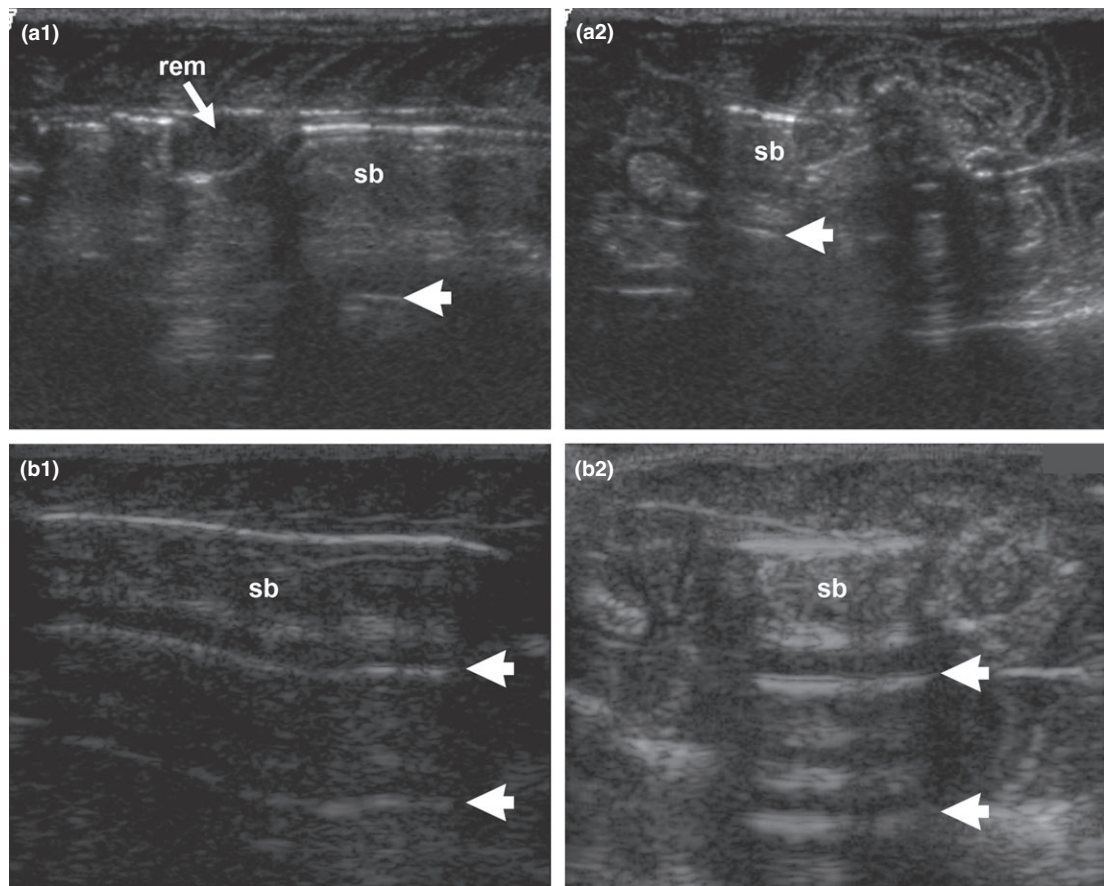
Anguilla anguilla*, no. 5. (a1) Longitudinal and (a2) transverse high-end ultrasonic images halfway through the swimbladder from eel in Fig. 1 taken with a 14 MHz linear transducer, showing the swimbladder (sb) and the rete mirabile (rem) with reverberation artefacts (short arrows). (b1) Longitudinal and (b2) transverse low-end ultrasonic images of the same swimbladder taken with a 5 MHz linear transducer, showing the swimbladder (sb) with reverberation artefacts (arrow heads).
